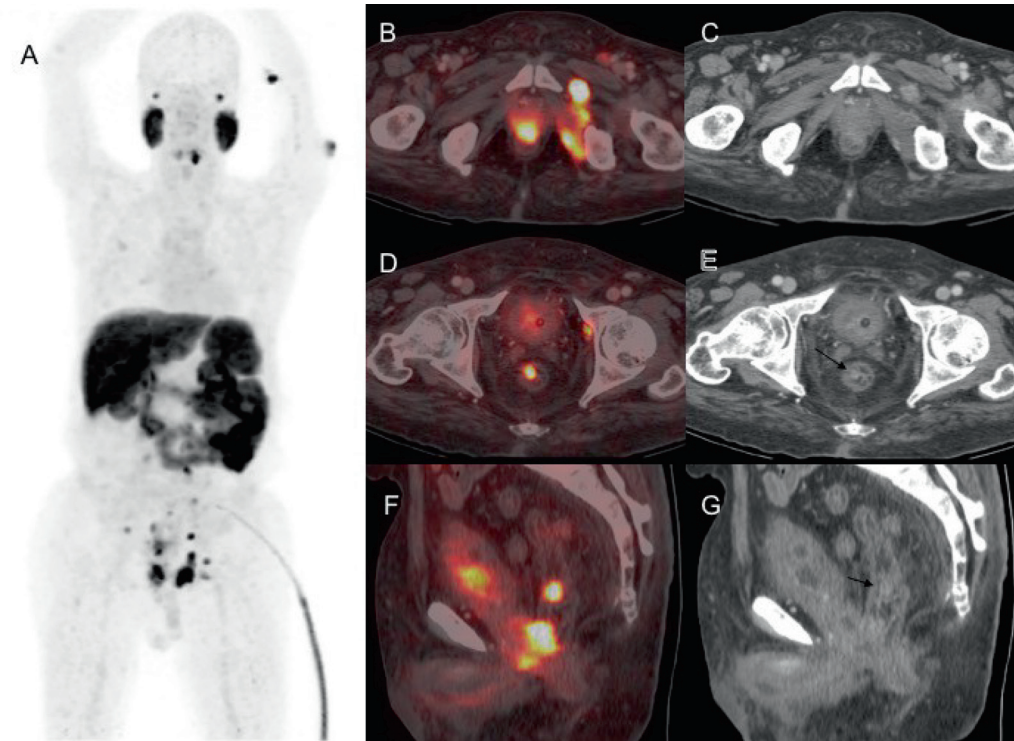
The maximum intensity projection image of whole-body Fluorine-18 prostate specific membrane antigen positron emission tomography/computed tomography (¹⁸F-PSMA-1007 PET/CT) (A) shows multiple foci of abnormal tracer uptake in the pelvis and abdomen. The transaxial fused PET/CT and contrast-enhanced computed tomography images showed increased uptake of radiotracer in primary tumor in prostate infiltrating the neck of urinary bladder, rectum, levator ani, and obturator muscles along with pelvic lymphadenopathy (B, C). An isolated PSMA avid enhancing nodule was also noted in the mucosal aspect of anterolateral wall of rectum away from the primary lesion in transaxial (D, E; black arrows) and sagittal (F, G; black arrows) sections.
